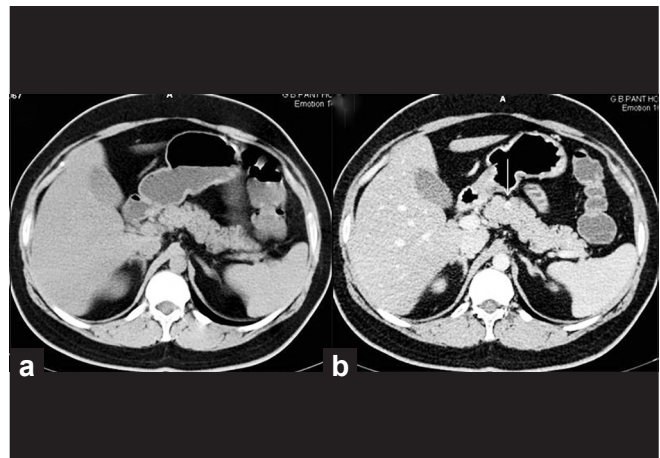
Functioning islet cell tumor: Insulinoma in a 55-year-old male patient who presented with hypoglycemic symptoms. Axial plain (a) and dual-phase contrast-enhanced CT abdomen obtained in portal venous phase (b) shows a well-defined intrapancreatic subcentimeter size mass (thin white arrow). The lesion is inconspicuous on non-contrast CT, however shows marked homogenous contrast enhancement in portal venous phase image
